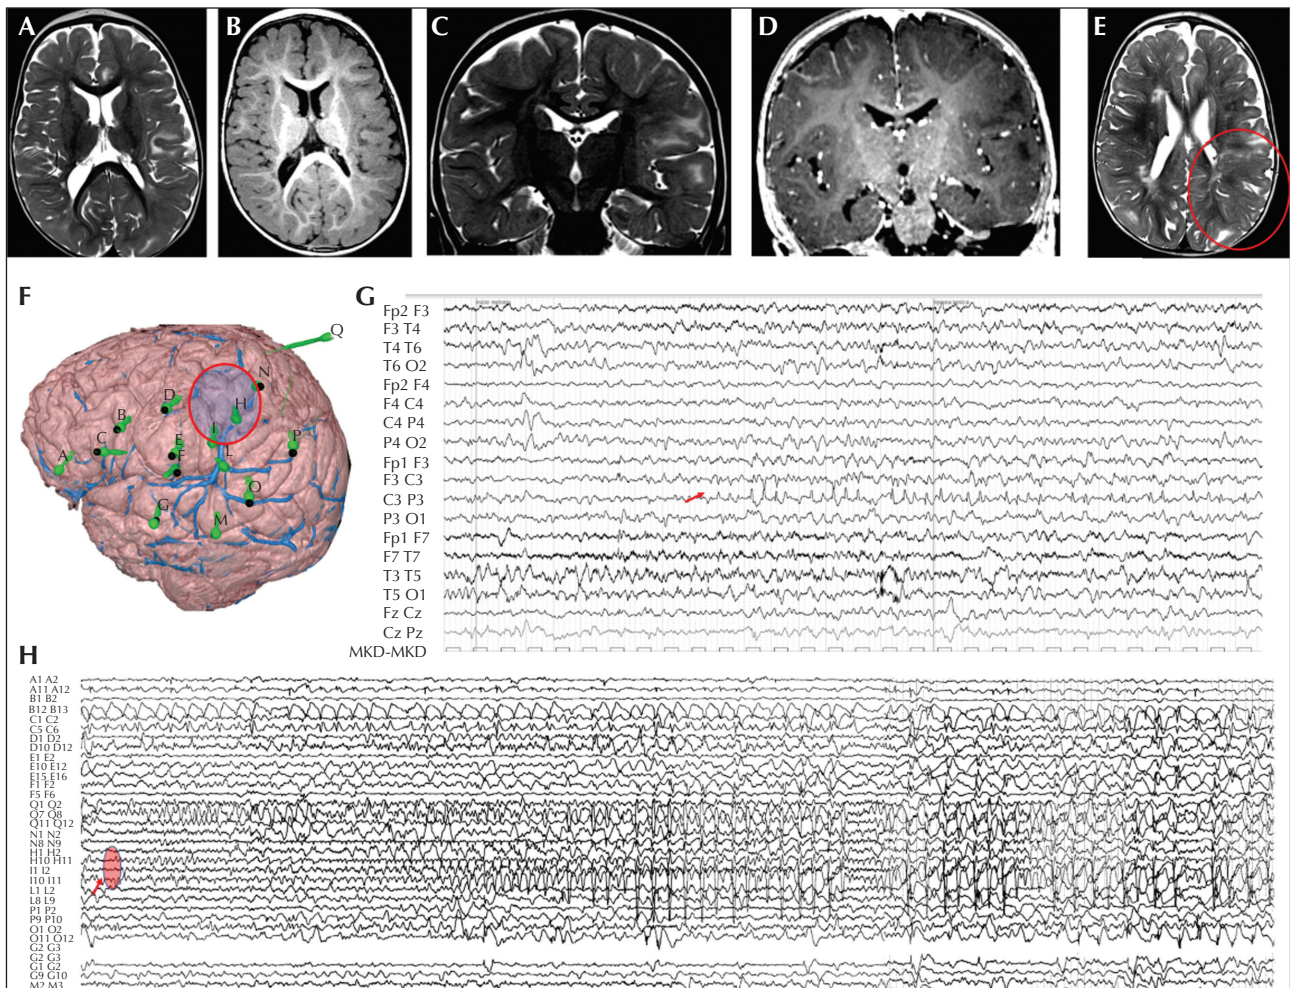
Presurgical evaluation of a two-year-old patient with a *TSC2* genetic variant and drug-resistant epilepsy. Seizures started at the age of two months. Neurological examination revealed right hemiparesis and cognitive delay. The patient presented with both focal right hemiclonic seizures and focal asymmetric epileptic spasms with right arm prevalence. (A-E) Brain MRI at the age of 20 months. (A-D) Axial and coronal T2 and T1-weighted sequences showing multiple hyperintense areas on T2-weighted sequences and hypointense on T1-weighted sequences for bilateral tubers. (E) Parietal postcentral tuber marked with a circle, showing blurring of the grey-white matter, which was explored using intracranial electrodes (N, H, I) and involved the seizure onset. (F) Intracranial SEEG exploration of the left hemisphere using 15 electrodes: eight electrodes (D, E, F, N, H, I, L, Q) were used to explore the perirolandic tuberal area; three electrodes (A, B, C) for the anterior frontal region; two electrodes (G, M) for the superior temporal gyrus; and two (O, P) for the posterior parietal region. (G) Video-EEG recording showing a focal seizure, with paroxysmal rhythmic discharge of spikes and sharp waves with phase reversal at electrode C3. Clinically, the patient presented with chin contractions, reduced awareness, inconstantly associated with left eye deviation. (F) SEEG recording showing a focal seizure starting as theta rhythmic activity over electrodes Q, N, H, I, evolving into spike-and-wave complexes, mixed with sequences of fast activity. Clinically, the patient demonstrated a mild reduction in responsiveness during the initial ictal discharge, followed by a brief tonic contraction of the right side during the fast activity.
